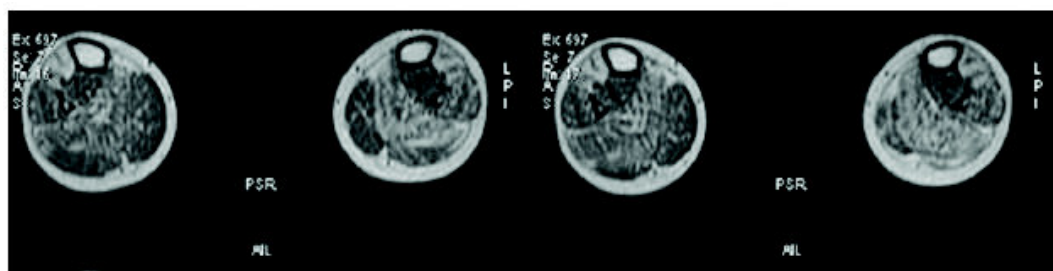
T1 Weighted Axial Musculoskeletal MRI image before cellular transplantation*
